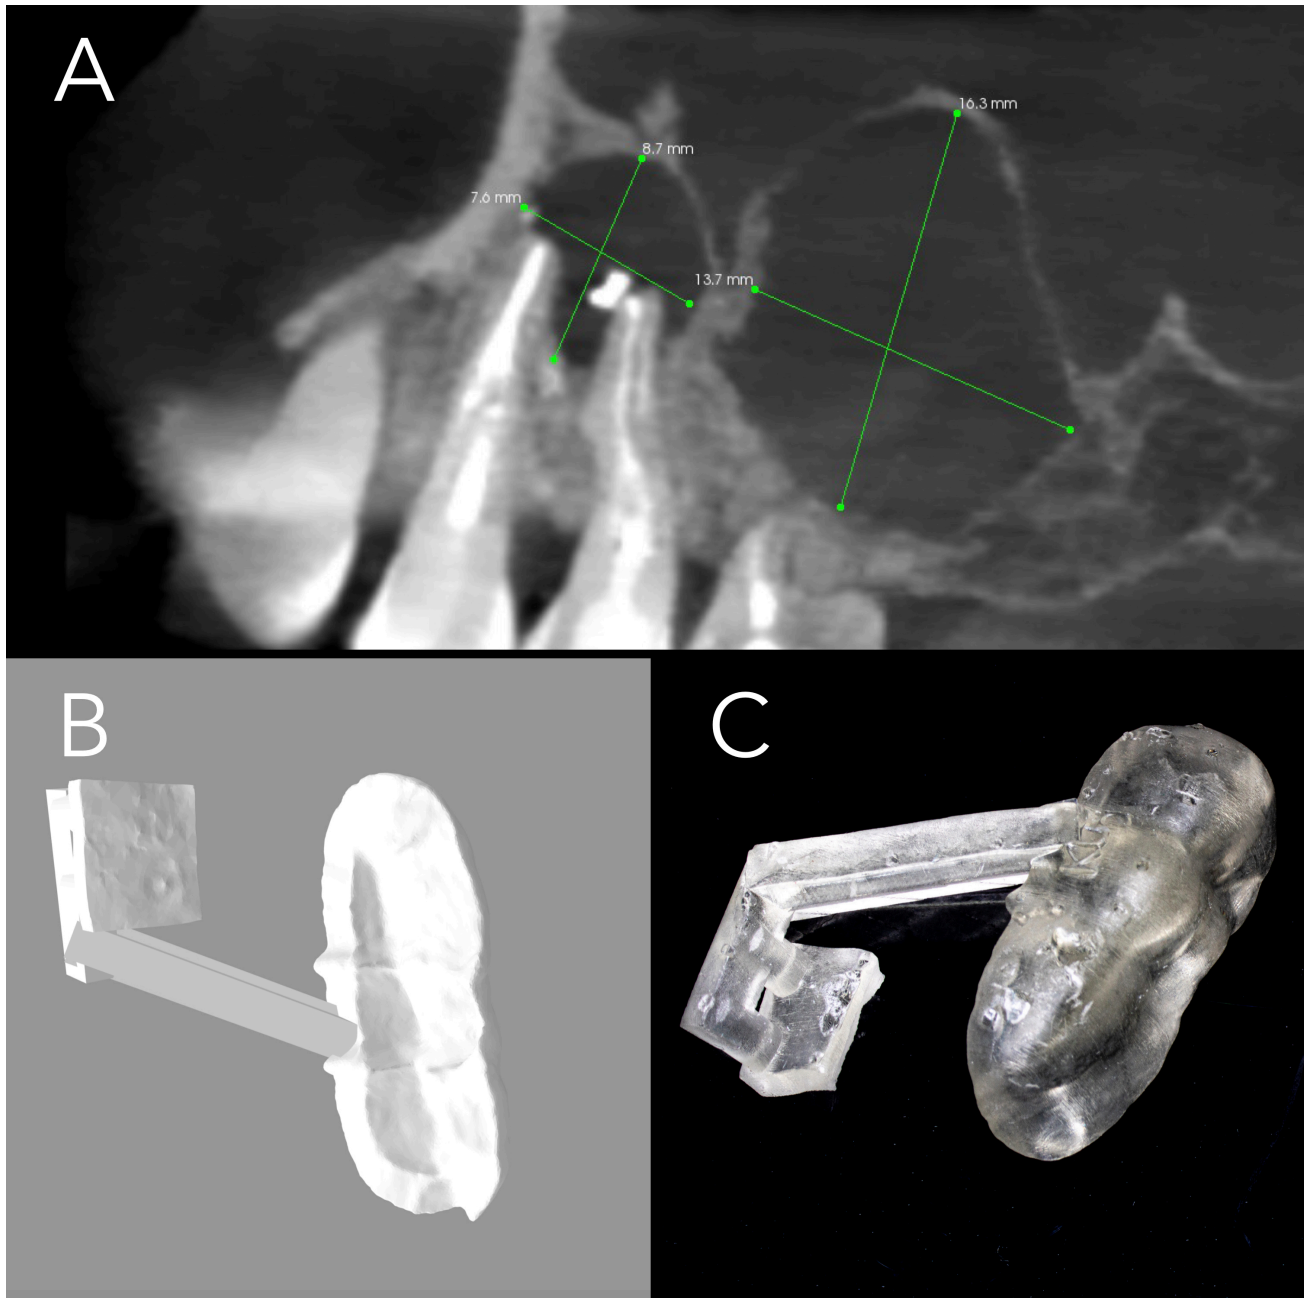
Fabrication of a surgical template. (A) CBCT image taken 12 months after root canal treatment, showing both lesions with measurements. (B) Design of the surgical guide. (C) Printed surgical guide.
